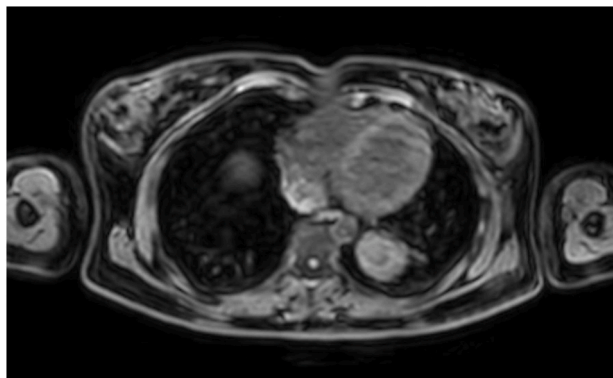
Dynamic magnetic resonance imaging of patient
